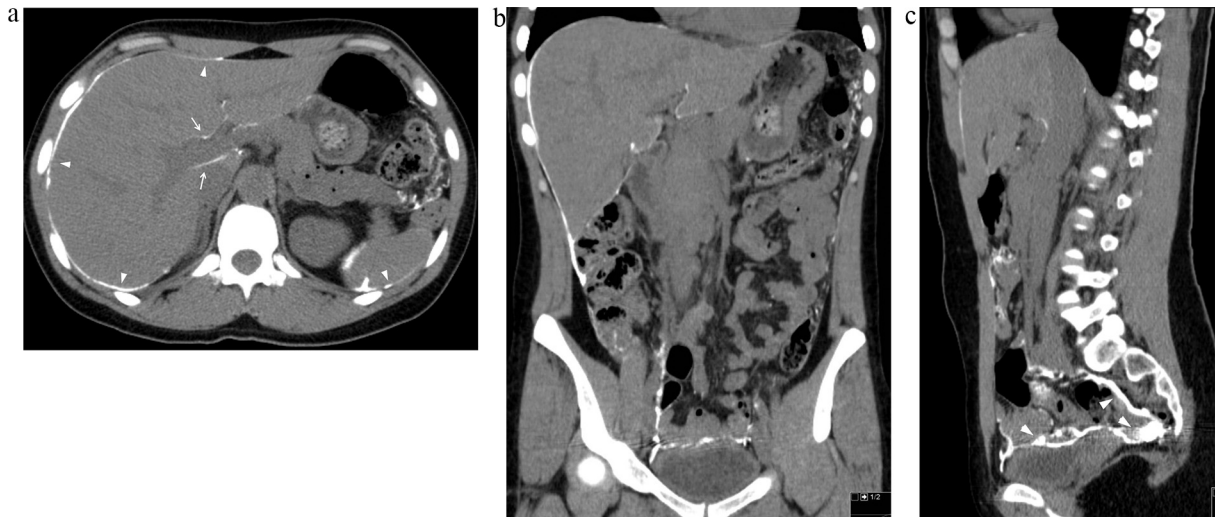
The abdominal CT without contrast revealed extensive visceral (arrows in a) and parietal peritoneal calcification (arrowheads in a) with areas of focal thickening in the pelvic peritoneum (arrowheads in c).
